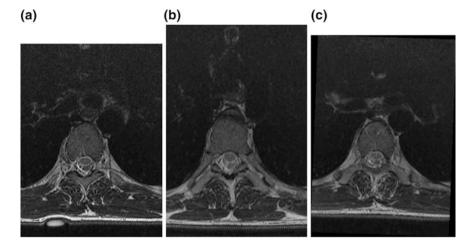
An axial cross-section of a 3D MR image of a normal spine, obtained by a orthogonal MPR, b oblique MPR and c orthogonal CPR
